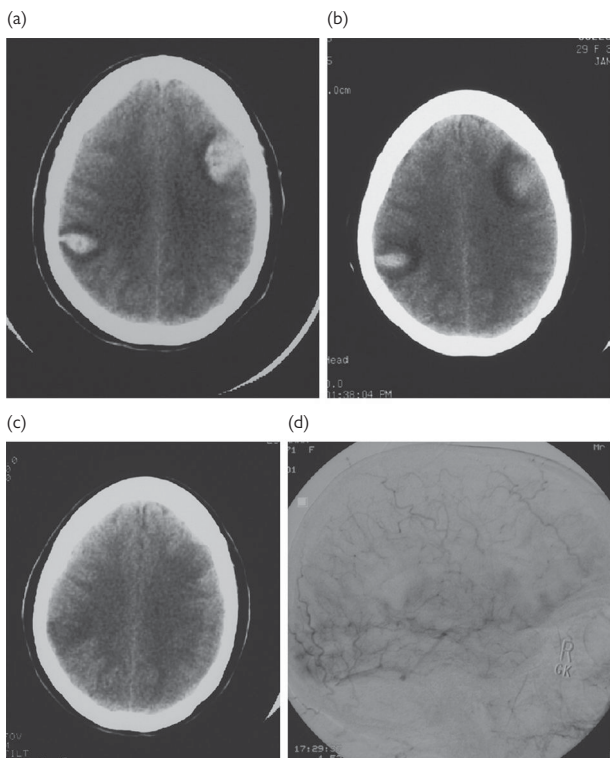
Cerebral venous thrombosis may present with headache, focal neurological signs and seizure, raised intracranial pressure, and impaired consciousness. This woman in her early thirties presented with reduced conscious level and seizures during the postpartum period. (a) CT scan showed haemorrhagic infarction in the left frontal region and right parietal region. (d) Intra-arterial venography shows no filling in the superior sagittal sinus consistent with superior sagittal sinus thrombosis. She was treated with heparin, and serial CT scans 8 (b) and 19 (c) days after the first scan showed progressive resolution of the haemorrhages. She made a complete recovery. © Hugh Markus.
